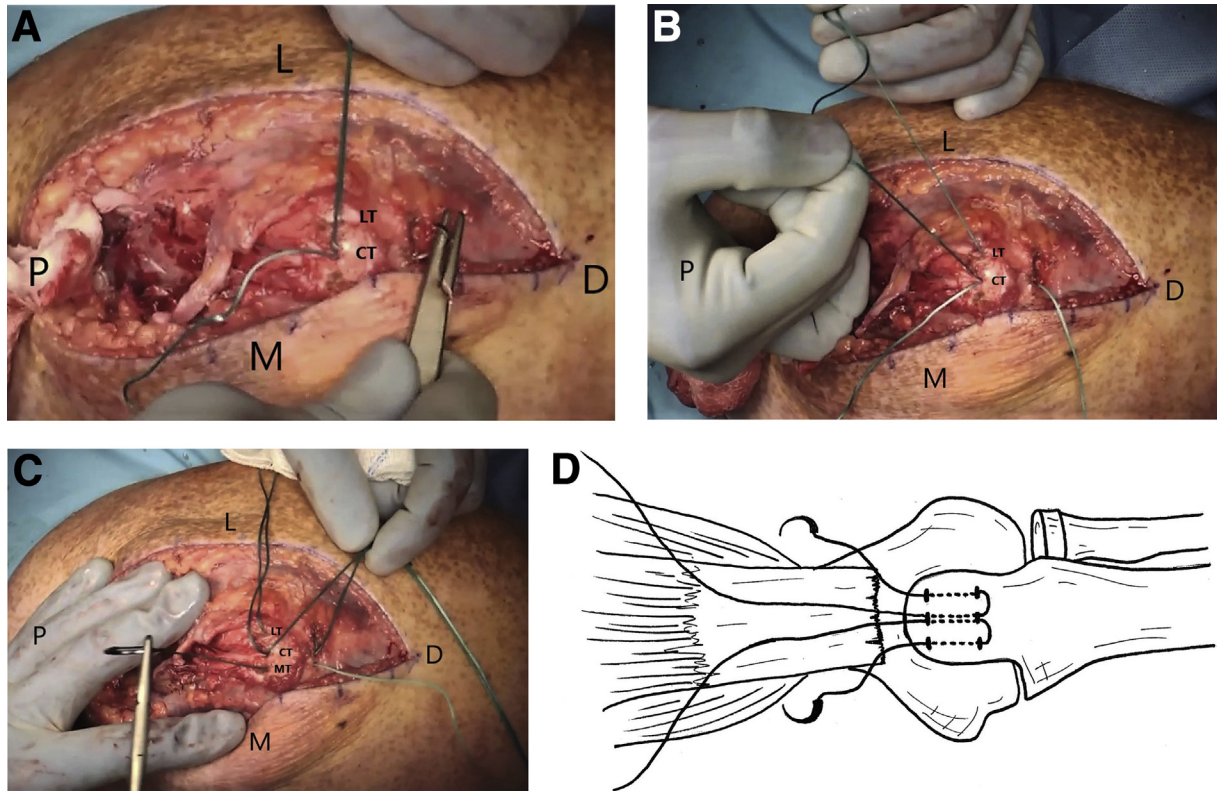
(A) A nonabsorbable high-strength suture, such as a No. 5 Ethibond (Ethicon) or a No. 2 FiberWire (Arthrex) is then passed antegrade through the central tunnel. (B) It is then shuttled retrograde through the most lateral tunnel. (C) After the first suture has been passed antegrade through the central tunnel, then shuttled retrograde through the most lateral tunnel. (CT, central tunnel; D, distal; L, lateral; LT, lateral tunnel; M, medial; P, proximal.)
